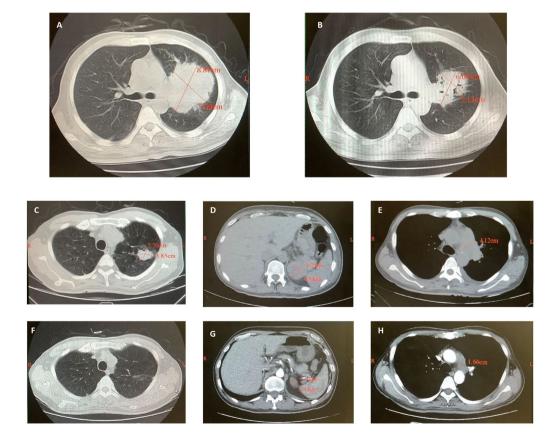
Computed tomography images showing the response to nab-paclitaxel combination therapy in two patients. Compared with lung lesions at baseline on 4 June 2015 (A), (B) shows a significant decrease in the size of lung lesions (24 August 2015) in patient #1 Y1285984 treated with nivolumab plus nab-paclitaxel. Compared with lung lesions on 28 May 2016 (C), adrenal gland on 1 July 2016 (D) and mediastinal lymph nodes on 1 July 2016 (E) at baseline, (F, G and H) show significant decreases in the size of metastatic lesions in another 53-year old male patient ,Y1881072, treated with nivolumab plus nab-paclitaxel.
